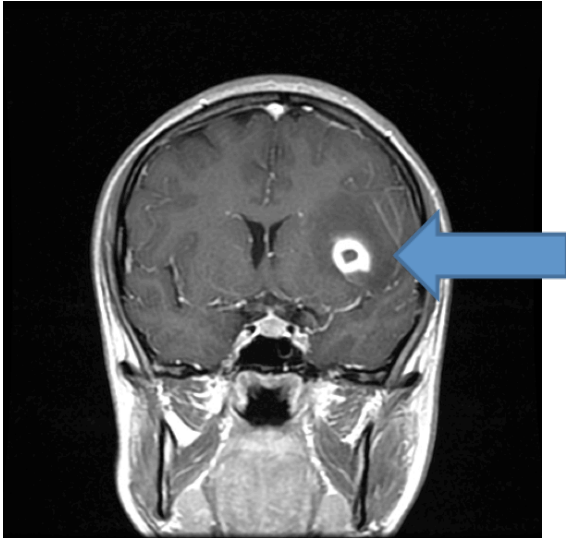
T1-weighted coronal MRI with contrast demonstrating a left-sided ring-enhancing lesion (arrow) surrounded by vasogenic edema and also a midline shift.
